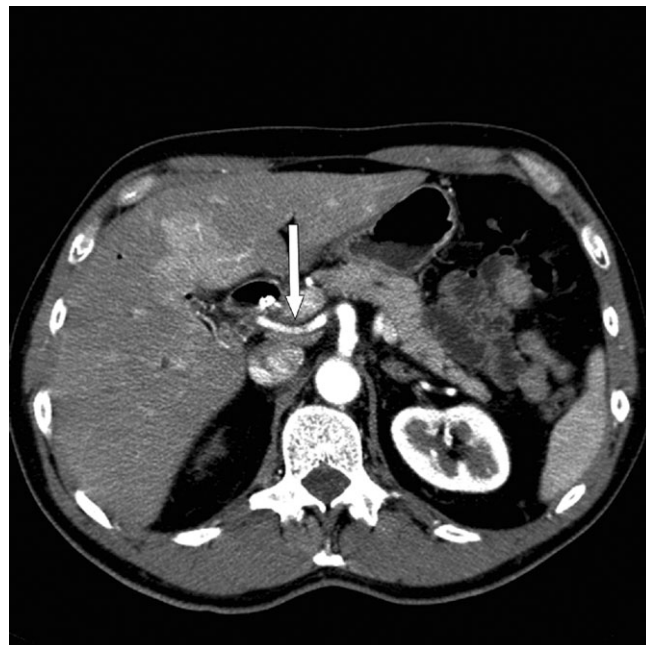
Computed tomography scan showing a replaced right hepatic artery (white arrow) arising from the superior mesenteric artery
